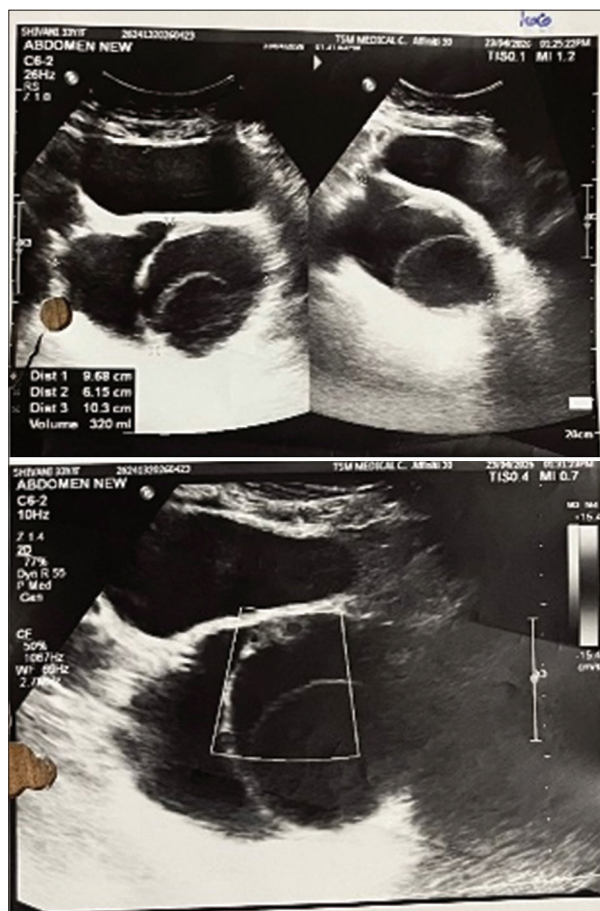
Ultrasonography whole abdomen showing a multiloculated complex cystic lesion with thick internal septations and an eccentric soft tissue component showing mild vascularity on color Doppler in the midline pelvic region, suggesting mild hepatomegaly
